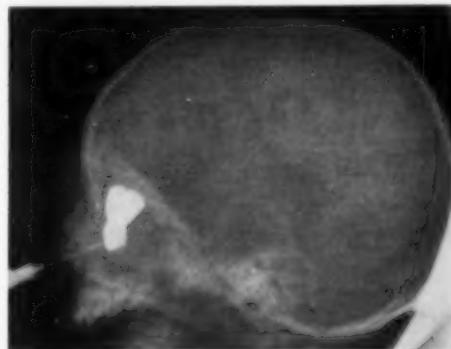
(Ladenheim and Metrick). Right lateral X-ray view at time of injection of radiopaque dye. Note soft tissue shadow.
